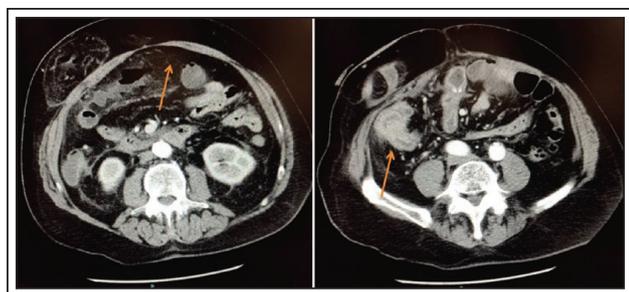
CT scan of the abdomen and pelvis with IV contrast demonstrating diffuse pneumoperitoneum (left) and thickening and enhancement of bowel wall near the ileoileostomy with associated fat stranding (right).
